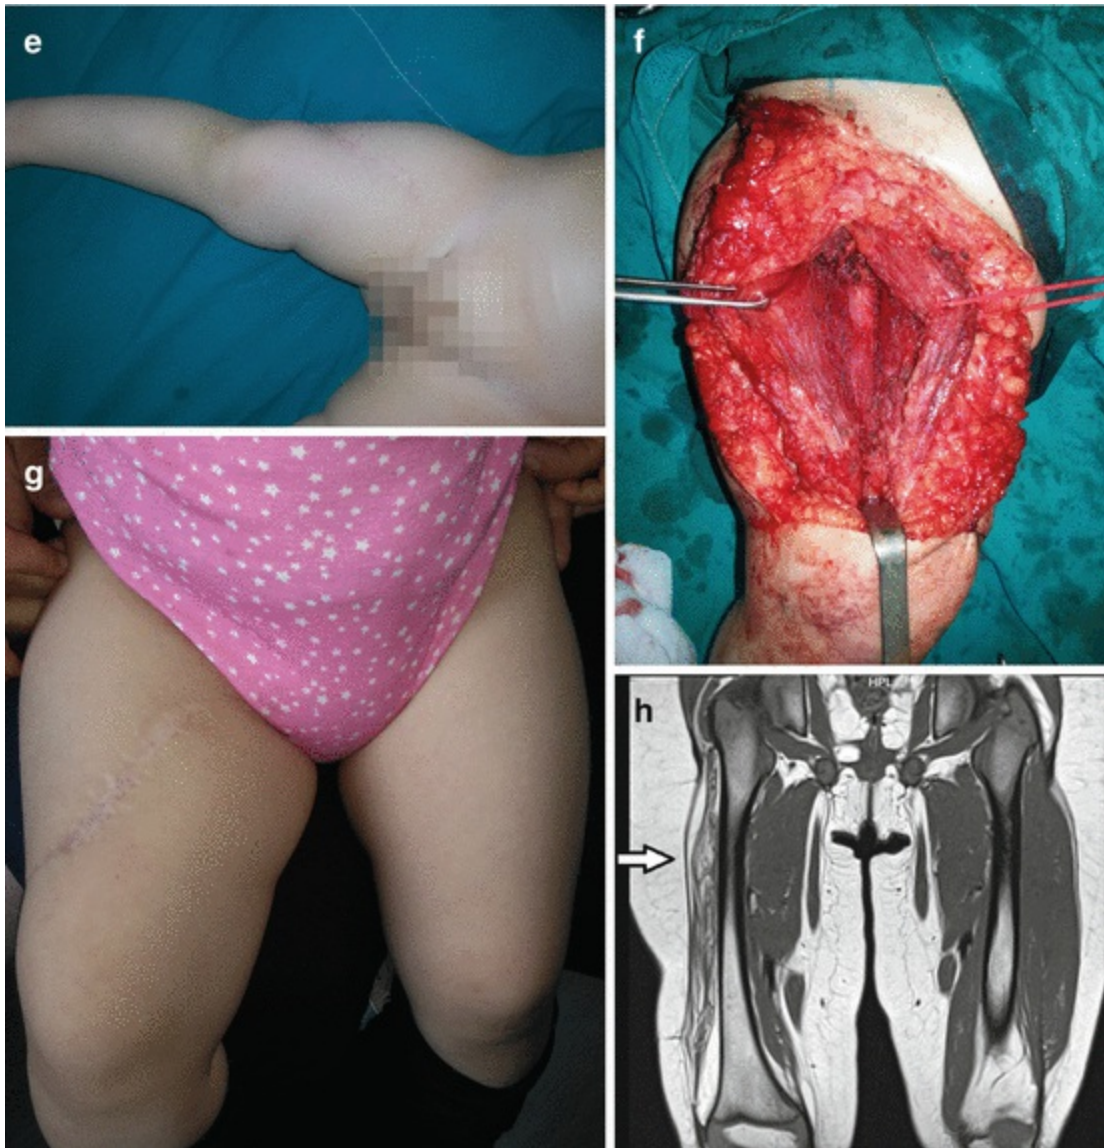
Infantile fibrosarcoma of the right femoral region: (a) preoperative view; (b) magnetic resonance imaging finding; (c) tumor biopsy; (d) magnetic resonance imaging finding prior definitive surgery; (e and f) excision of the tumor; (g) 2-year postoperative finding; (h) magnetic resonance imaging finding revealing no presence of tumor
